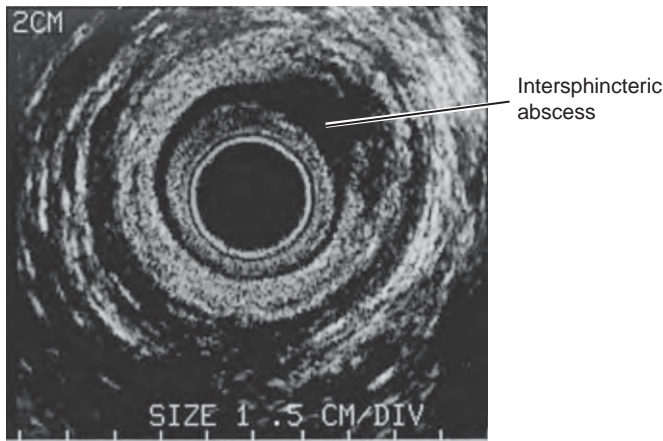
Intersphincteric abscess as seen with the use of transanal ultrasound.
